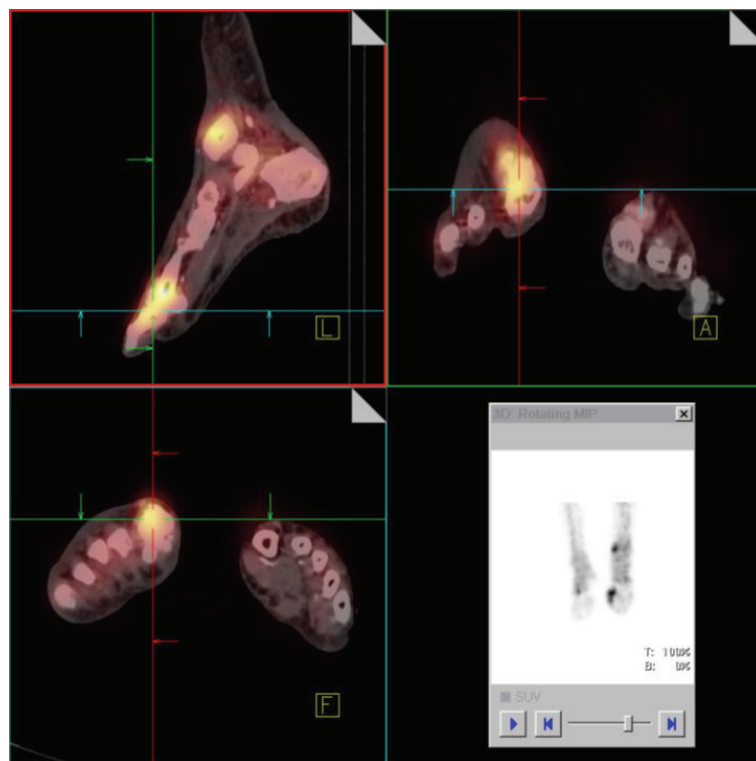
Merged SPECT/CT imaging of the lower extremities localizes the increased tracer uptake exactly at the distal tibia and MTP I.
